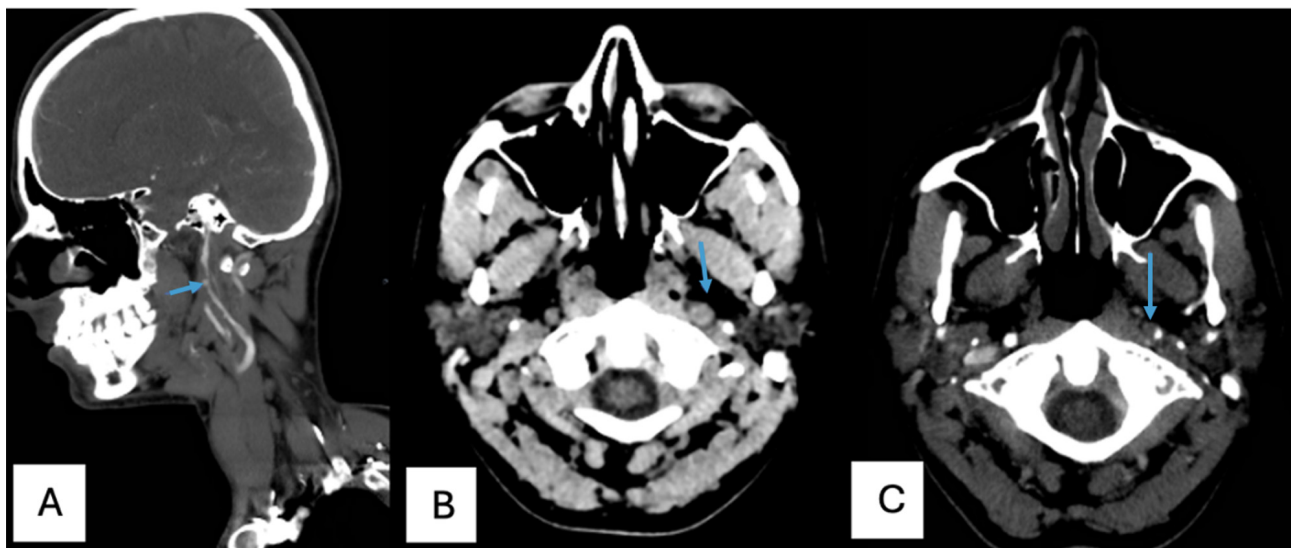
Computed tomography (CT) angiogram and the CT of the head showing the left internal carotid artery dissection. (A) Sagittal reconstruction of the CT angiogram showing the left internal carotid artery dissection (blue arrow). (B) Unenhanced CT of the head at skull base showing the left internal carotid artery dissection flap (blue arrow). (C) Axial CT angiogram showing the left internal carotid artery dissection with filling defect (blue arrow).
